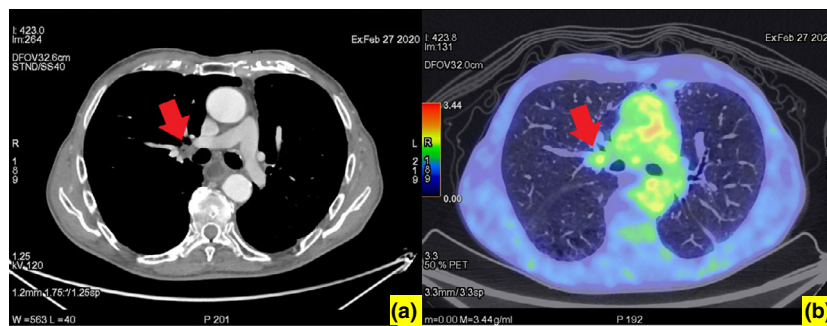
High-resolution CT transaxial (a) and ^{18}F -FDG PET/CT transaxial (b) images.
